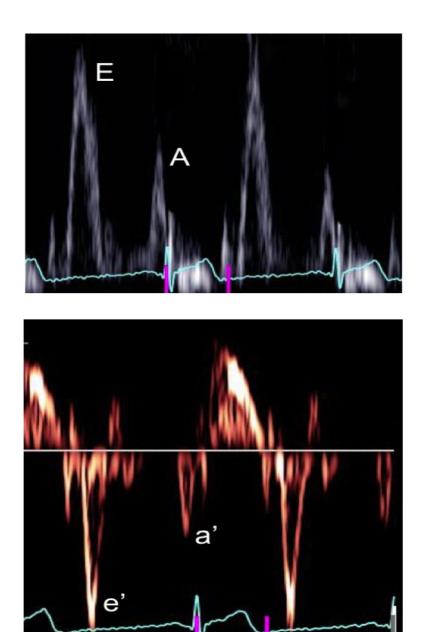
Example of echocardiographic images of pulsed wave Doppler transmitral E wave (E) and A wave (A) velocities (upper panel), and TDI peak myocardial early (e') and late (a') diastolic velocity at the mitral annulus(lower panel) used to assess diastolic function.
